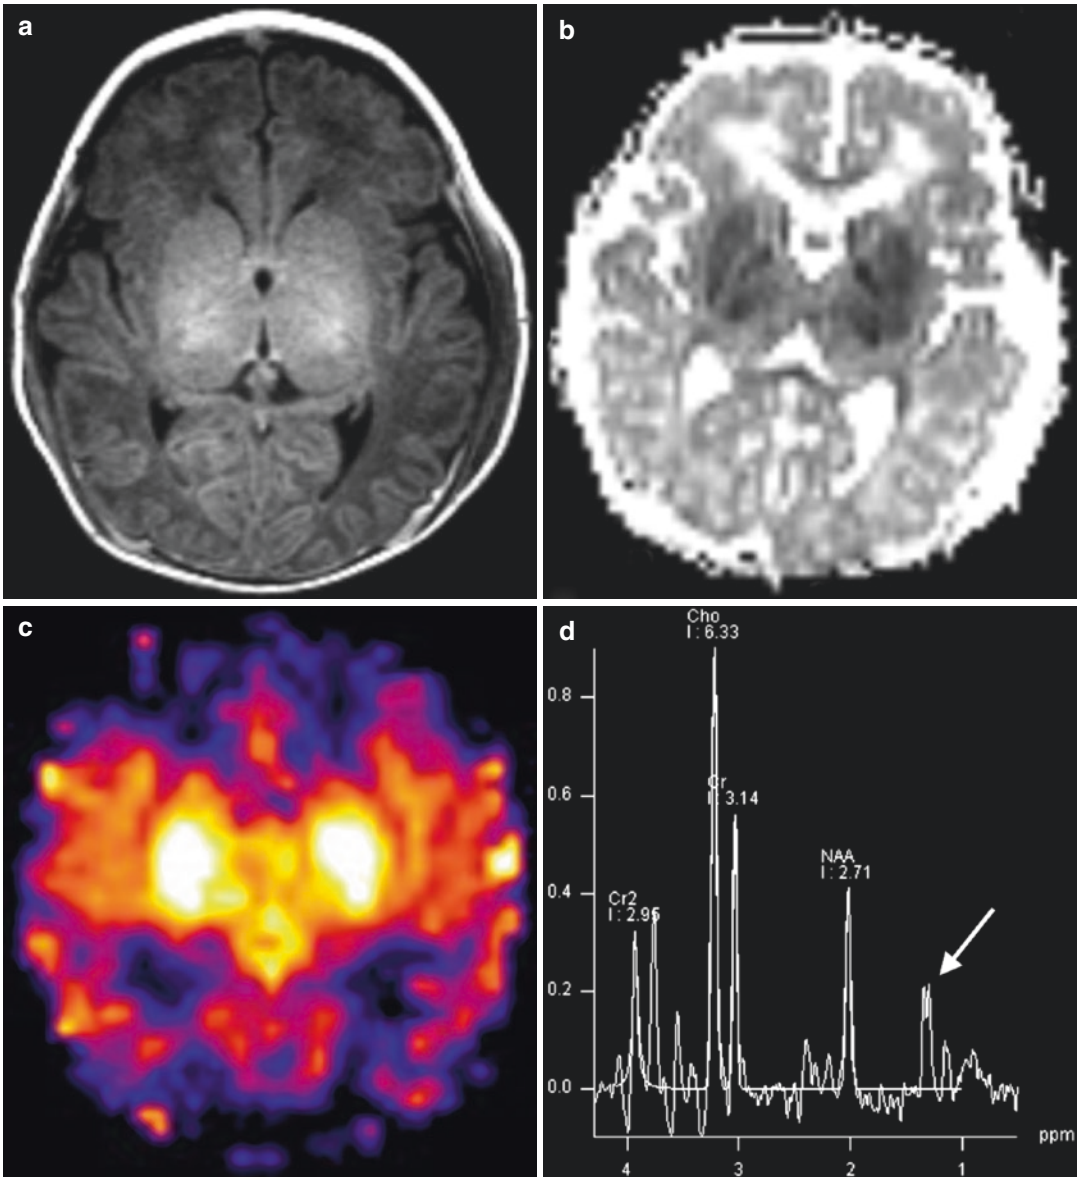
Neonate with seizures after emergency caesarean section delivery due to close on full abruption, showing a deep profound pattern of hypoxic injury. (a) T1-weighted image demonstrates subtle increased signal in the basal ganglia and parts of the thalamus. Differentiating abnormal signal from normal myelination in the lateral thalamus and posterior limb of internal capsule may be difficult. (b) Apparent diffusion coefficient
